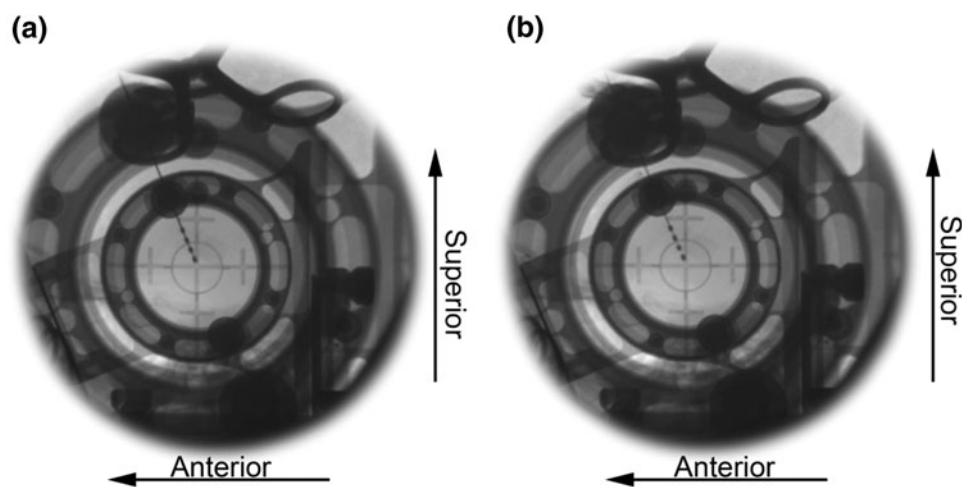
Intraoperative lateral radiographs Lateral radiographs through the CRW frame before (a) and after (b) removal of the rigid internal stylet are shown. Targeting cross hairs on one side of the frame are aligned with concentric circles on the other to indicate a true lateral projection. No obvious brain shift is apparent after the removal of the outer rigid insertion cannula and internal rigid stylet.
